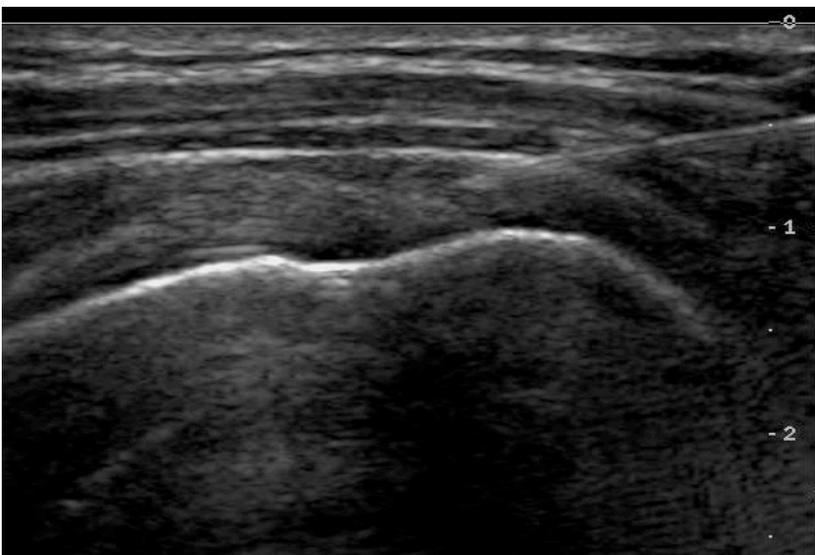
Ultrasound guided needle
